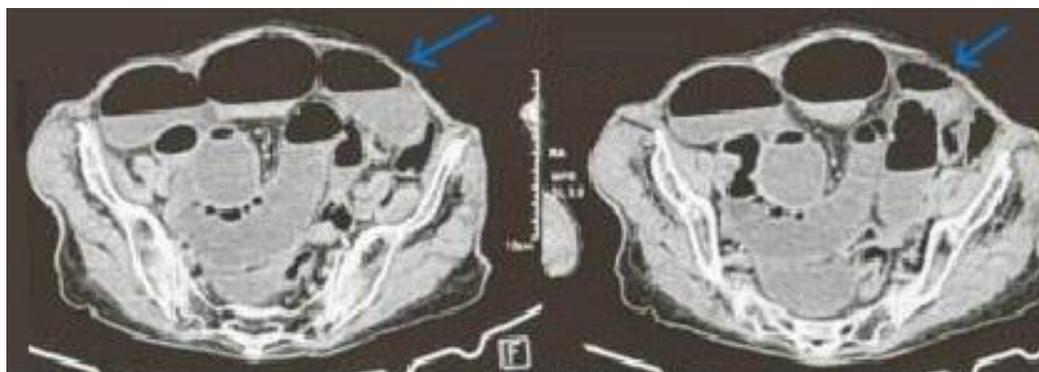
CT image showing the transitional level. Blue arrow
